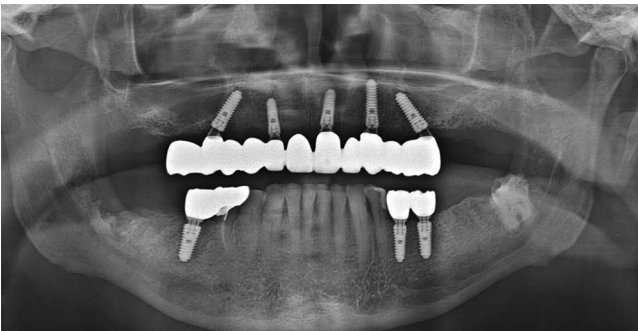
A panoramic radiograph was taken 4 months after implant placement at the time of final prosthesis delivery. The image shows 5 maxillary and 3 mandibular MegaGen AnyRidge implants supporting a full-arch zirconia prosthesis in the maxilla and individual zirconia crowns in the mandible.
